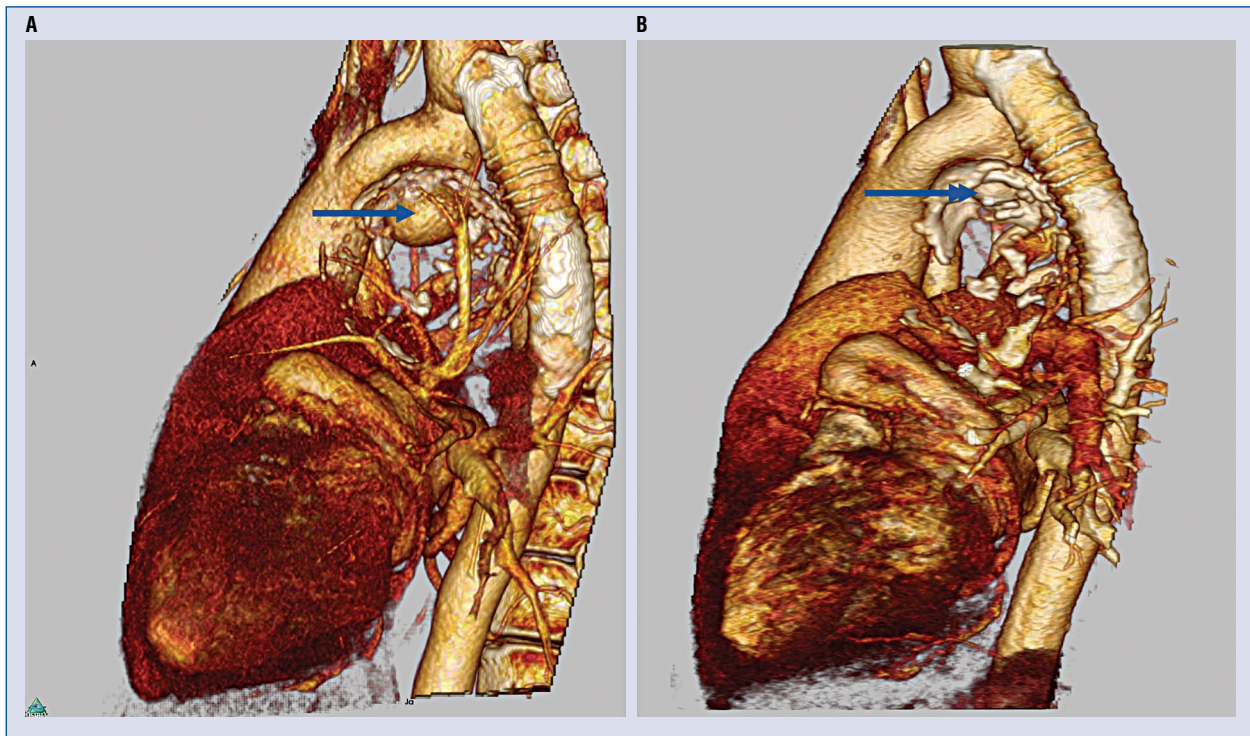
Computed tomography volume rendering reconstruction showing the anatomy before the procedure (A) and after (B). The arrows show the aneurysm on the lesser curvature of the aortic arch and the ADO implanted to close it. Detailed description in the text.
